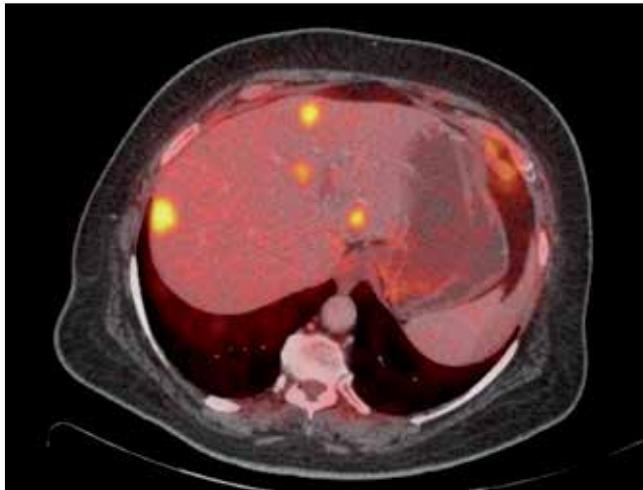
PET/CT Cancer pancreas with liver metastases (<http://www.radrounds.com/photo/petct--2context>).
